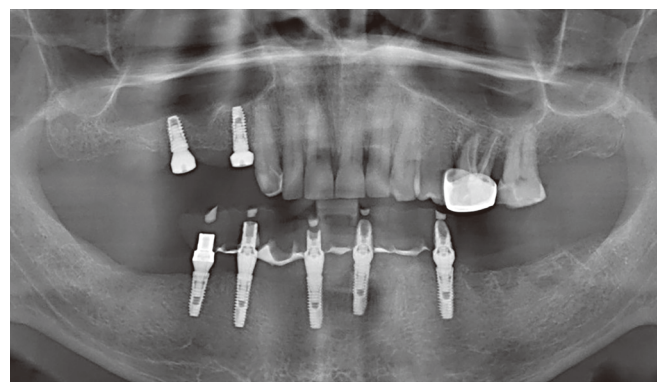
CBCT scan 5 months later. A severe bone loss on the lower jaw is gone.
